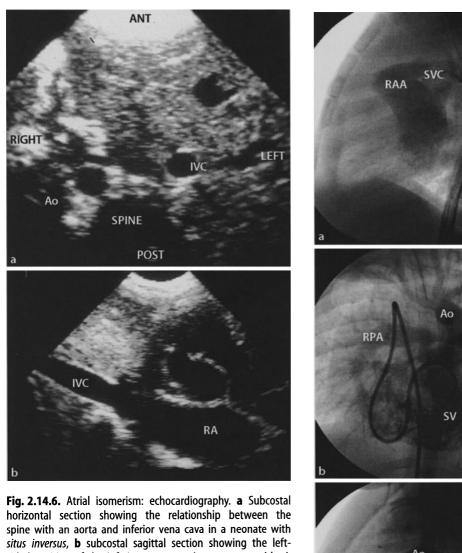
Atrial isomerism: echocardiography. a Subcostal horizontal section showing the relationship between spine with aorta and inferior vena cava in a neonate with *right* isomerism (*Ao* aorta, *IVC* inferior vena cava), b subcostal sagittal section showing the relationship between aorta and inferior vena cava in a neonate with *right* isomerism, c transesophageal echocardiography showing the *right* atrial isomerism in a neonate with double inlet right ventricle (*RA* right atrium, *RAA* right auricular appendage) (photographs courtesy of Dr. Michael Rigby)
